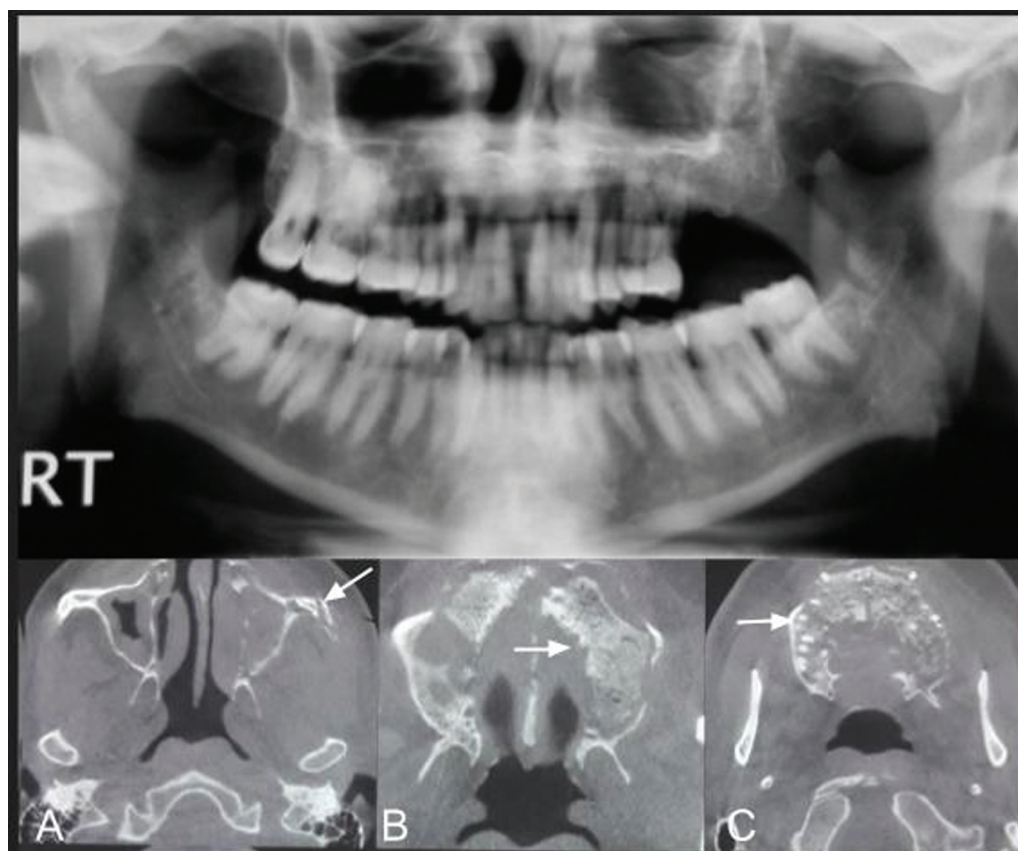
Bacterial osteomyelitis of maxilla. Orthopantomogram (OPG) and computed tomography (CT) show permeative destruction of the maxillary alveolus (white arrow in B), hard palate (white arrow in C), left-sided maxillary walls, and left zygomatic arch (white arrow in A).
